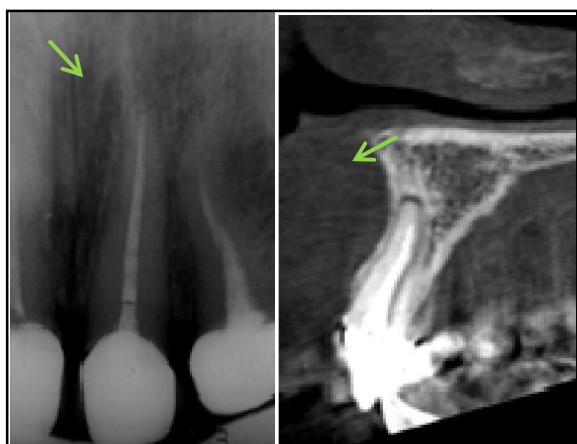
X-ray and CBCT of the tooth 21
